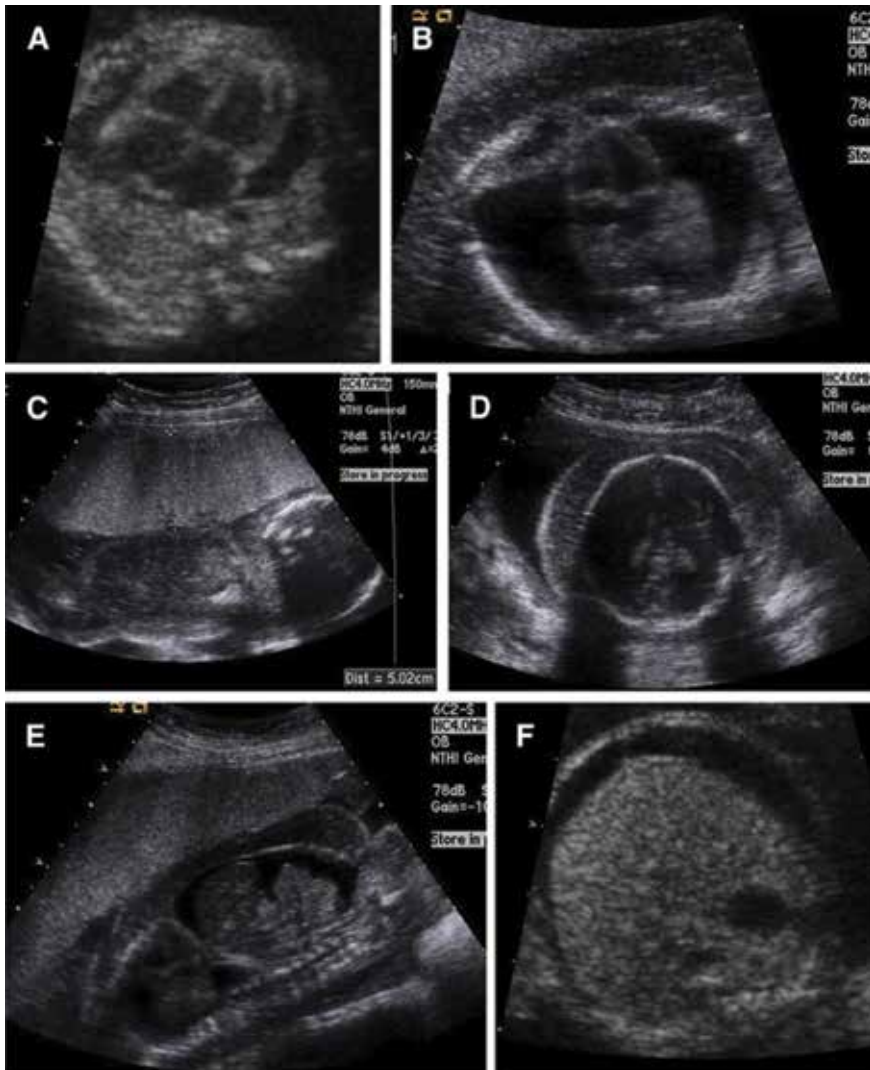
Ultrasound findings fetal hydrops [1]. (A) Pericardial effusions, (B) pleural effusions; note: midline heart anterior to small lungs with bilateral effusions, (C) placental thickening, with placenta measuring >4 mm in thickness, (D) skin thickening at level of fetal skull, (E) ascites, sagittal, with free-floating loops of bowel surrounded by ascites, and (F) ascites in upper abdomen, at level of fetal liver and stomach [1].*
